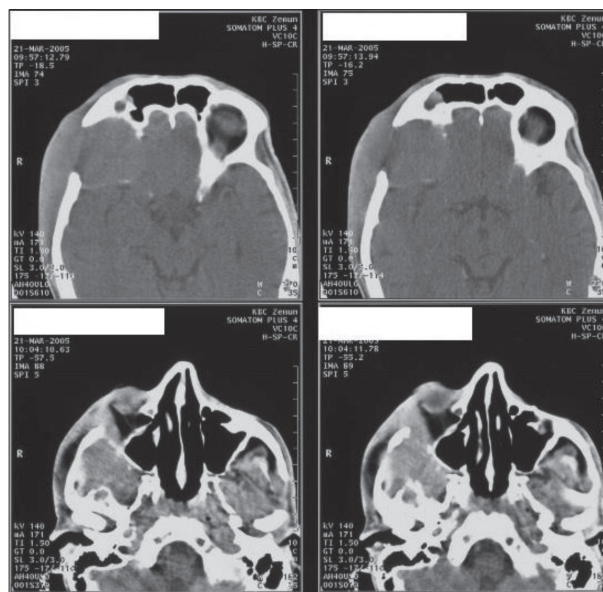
Computed tomography scan of the endocranium, showing a tumor infiltrating the base of the skull, zygomatic bone, and the walls of the orbit, with penetration in the endocranium
